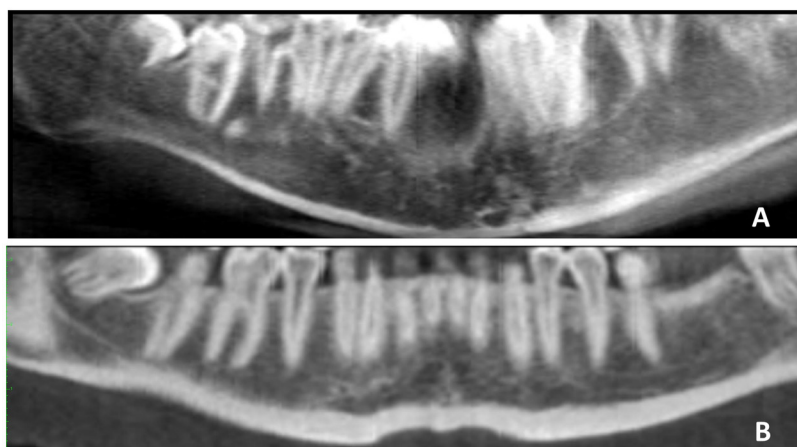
CBCT panoramic view showing: (A) Thinned smooth edge of the mandible in a CP patient, G1; (B) thick mildly edge of the mandible in a control subject, G2.
